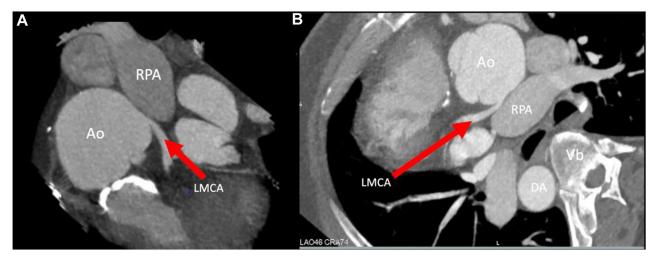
Cardiac computed tomography, multiplanar reconstruction, oblique axial displays focused on the heart (A) and showing the complete chest (B), demonstrates the posterior rotation of the reimplanted LMCA (*arrow*) coursing between the RPA and the ascending aorta (Ao). *DA*, Descending aorta; *Vb*, vertebral body.
